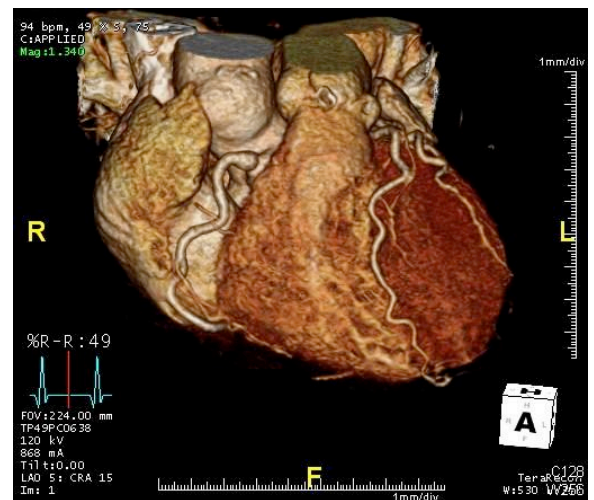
Three-dimensional (3D) reconstruction CTA image, showing proximal ectasia of the right coronary artery.
